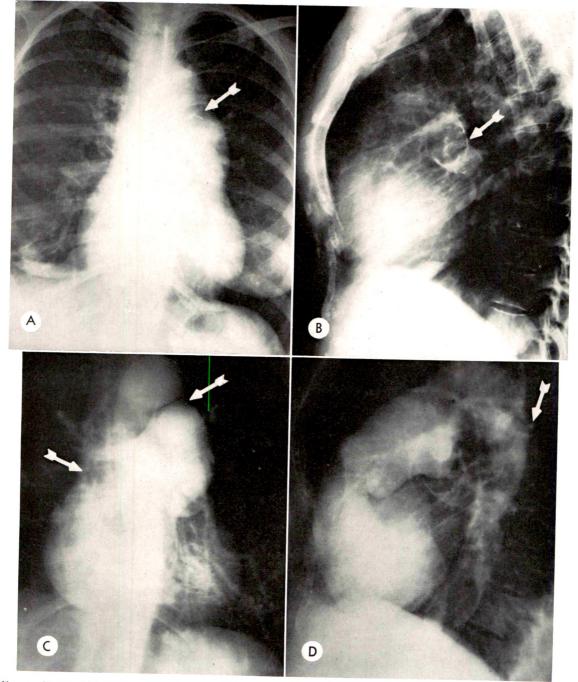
Reversed blood flow through a patent ductus arteriosus in a 47 year old woman with calcification of the pulmonary artery. (A) Frontal teleroentgenogram of the chest showing enlargement of the heart and pulmonary artery. The pulmonary artery is calcified (arrow). There is a plaque in the aortic knob and another between the aorta and pulmonary artery at the site of the patent ductus. (B) Lateral roentgenogram showing cross-sectional calcification of the left pulmonary artery (arrow). (C) Frontal intravenous angiocardiogram showing opacification of the descending aorta through a patent ductus arteriosus (left-sided arrow). Arrow on the right points to thrombus occupying over half of the diameter of the right pulmonary artery. (D) Lateral angiocardiogram shows the huge pulmonary artery with opacification of the descending aorta (arrow), via a patent ductus arteriosus. (Reproduced with permission of the Am. J. Med.⁸)
